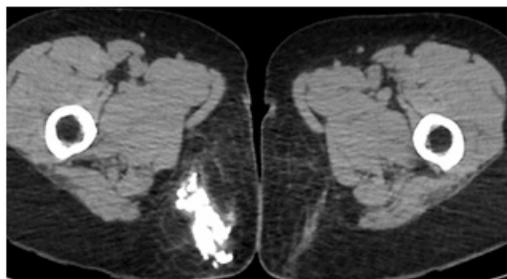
Pelvic CT-scan showing calcified polylobed lesion of the right buttock (approximately 7.5x4cm), surrounded by minimal contrast enhancement of deep subcutaneous fat
